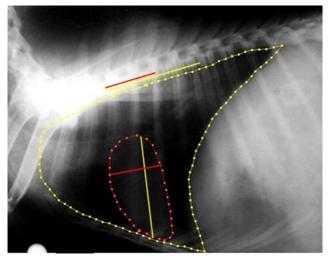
Right lateral thoracic radiograph demonstrating objective evaluation of cardiac size through vertebral heart score and cardiothoracic ratio.
